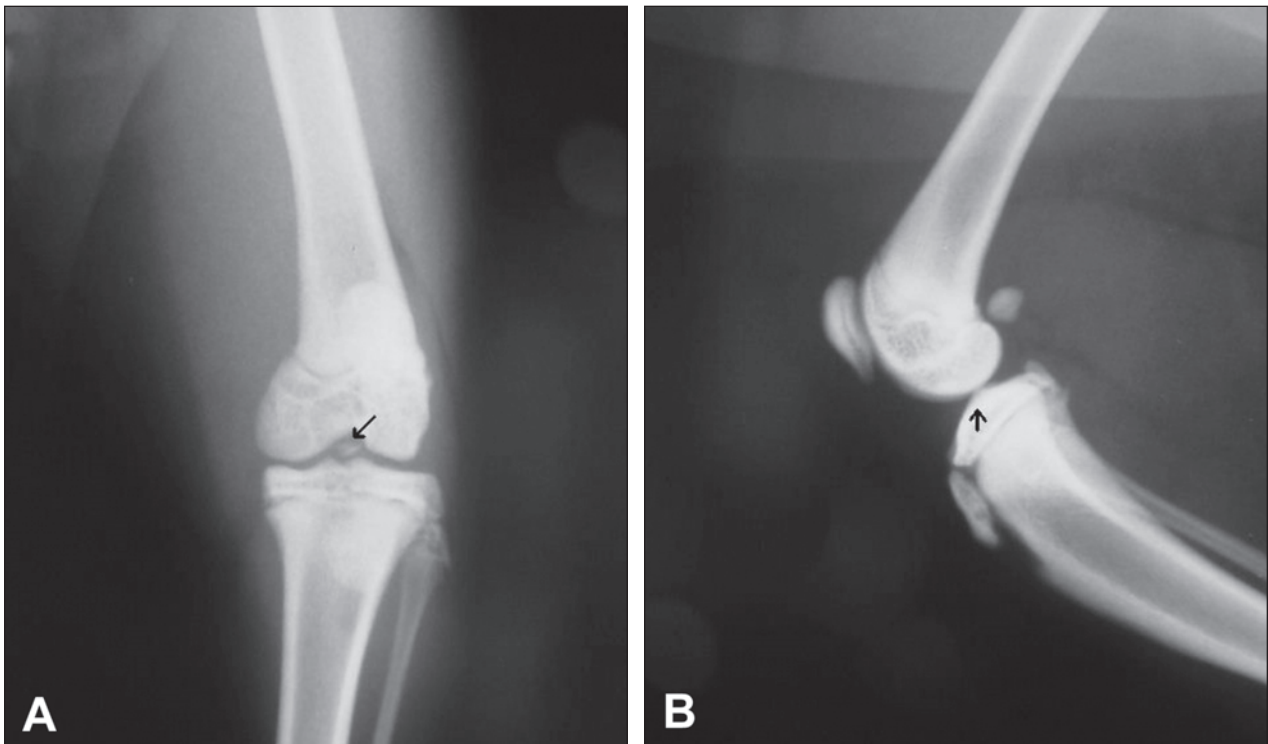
Same radiographic views as Figure 1. Notice the intra-articular avulsion fracture of the left tibia at the insertion of the cranial cruciate ligament (arrow).
